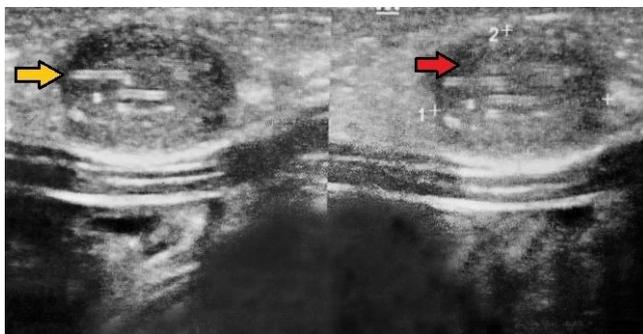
Ultrasonography showing an echogenic tubular structure (yellow arrow head) within hypoechoic lesion (red arrow head) in the subcutaneous tissue plane.
